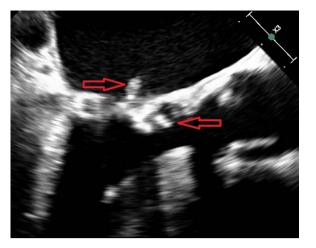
Transesophageal echocardiogram (TEE) showing two small mobile masses. One appears on the ventricular aspect and the other on the atrial aspect of bioprosthetic mitral valve.
